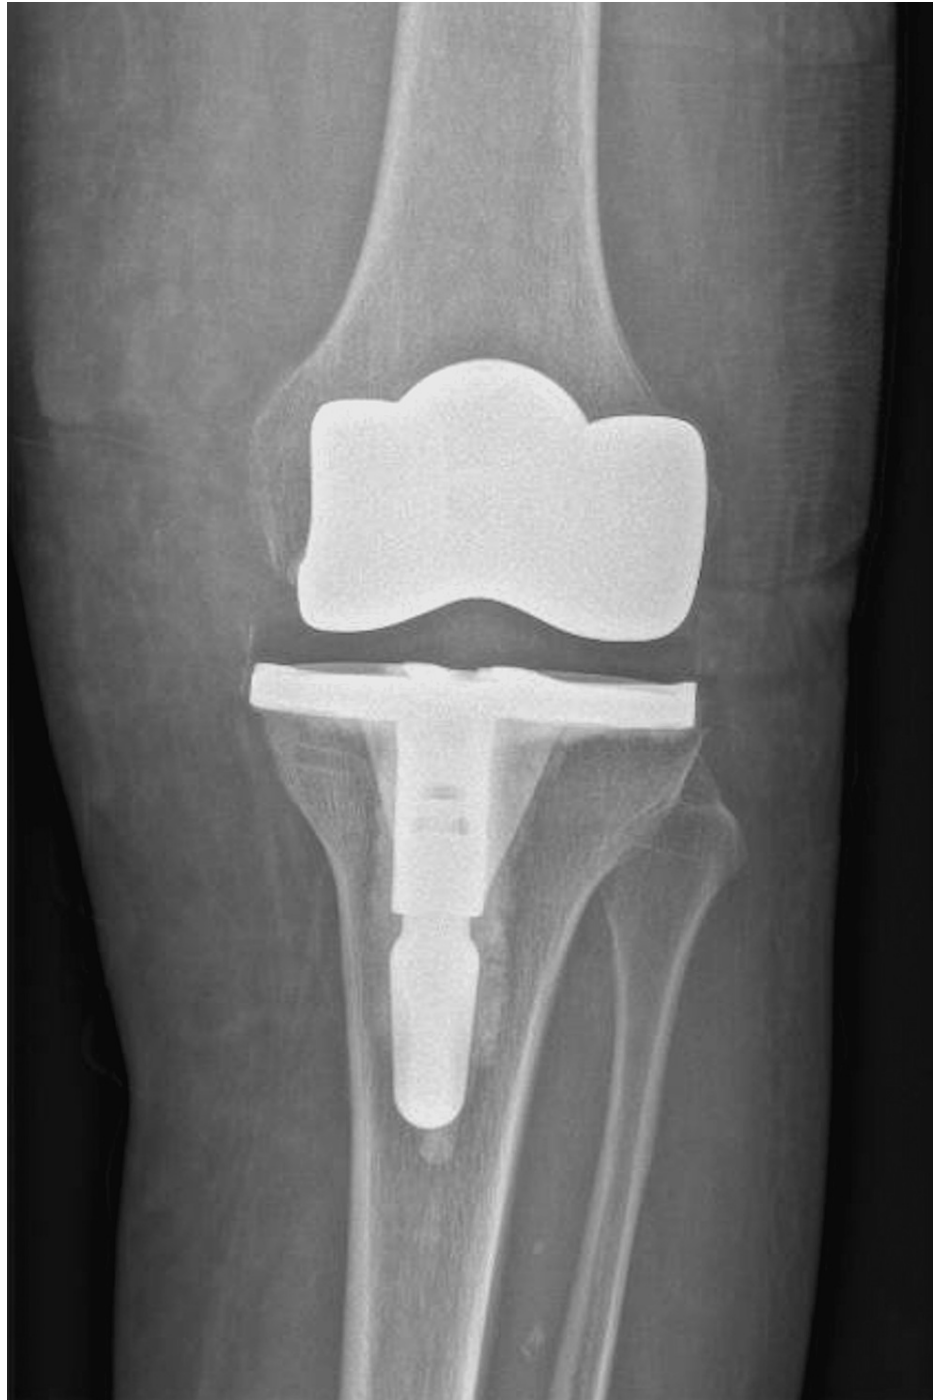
Radiographic control at the 16-month follow-up after debridement, antibiotics, and implant retention.
